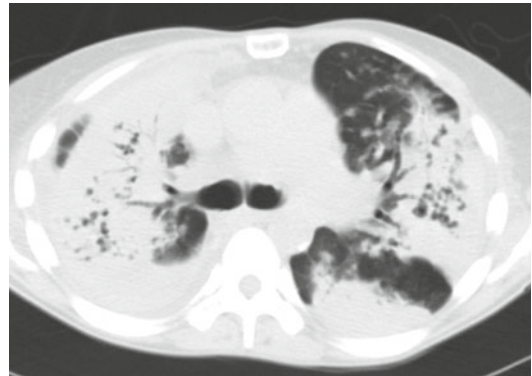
Axial CT image reveals widespread parenchymal consolidation with pseudocavitation. Bronchoscopy revealed multifocal mucinous adenocarcinoma
